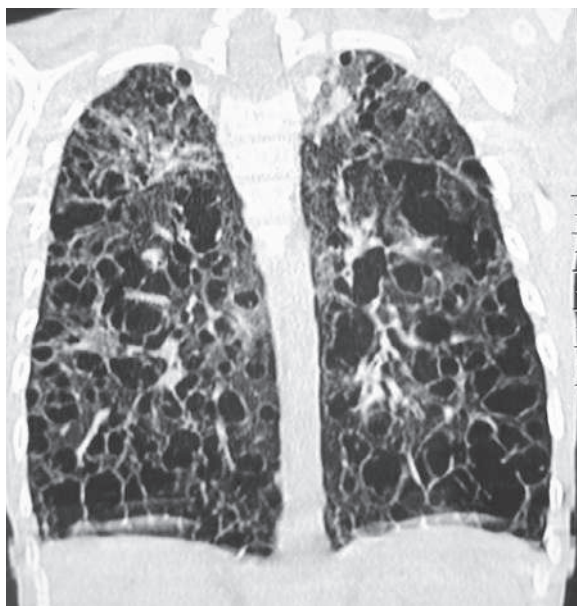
High-resolution coronal CT image (lung window) reveals diffuse lung cysts with parenchymal destruction in bilateral lung fields. (From Chauhan L, Aggarwal N. Honey-comb Langerhans cell histiocytosis. *J Pediatr*. 2016;168:248. Fig. 2.)
